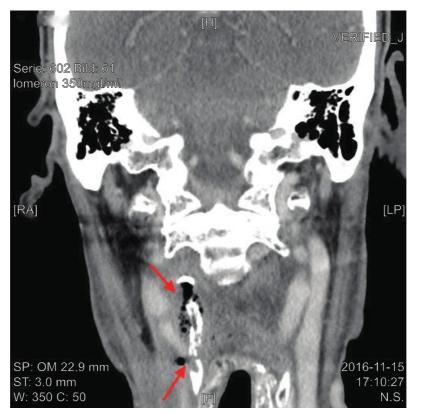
A 71-year-old man with a history of advanced base of tongue cancer, treated with chemoradiotherapy. A contrastenhanced CT of the head and the neck in coronal view shows a fracture line of the right thyroid cartilage (lower arrow), illdefined cortical destruction, and extensive gas bubbles adjacent to the thyroid cartilage (upper arrow). These findings suggest the presence of necrotic tissues.
